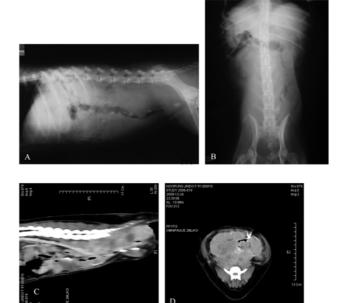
Lateral (A) and ventrodorsal (B) abdominal radiographs of case 5 showing ill-defined, extensive soft tissue masses in the retroperitoneal space and perianal region with severe ventral displacement of descending colon. Sagital (C) and axial (D) planes of post-contrast computed tomograhic reformatted images of case 5 showing extremely large, hypoattenuated and heterogeneous masses in the retroperitoneal space and perianal region. The masses surround the abdominal aorta, iliac arteries and veins, causing to displace ventrally.
